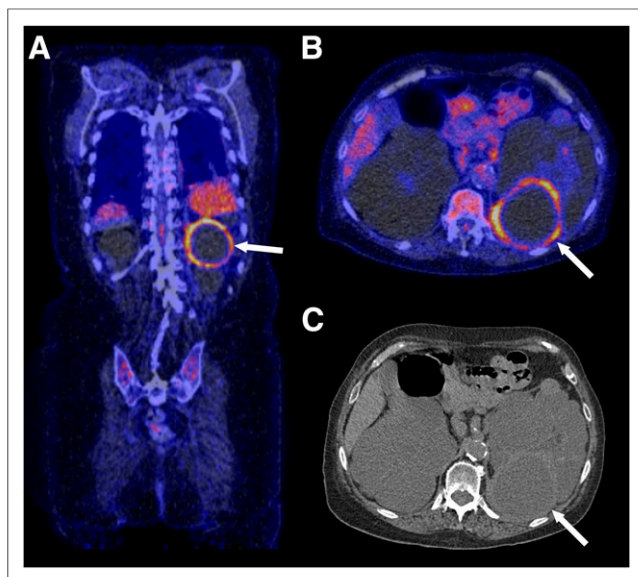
A 79-y-old woman who had ADPKD and whose ^{18}F -FDG PET/CT results were positive for renal cyst infection. (A and B) Coronal (A) and axial (B) fused ^{18}F -FDG PET/CT showed ^{18}F -FDG-avid cyst wall in left kidney (arrows), indicative of infection. (C) Axial CT at same level showed cyst (arrow) with slightly thickened and hyperattenuating wall. Criteria of Sallée et al. (5,10–13) for cyst infection were also met in this patient.
